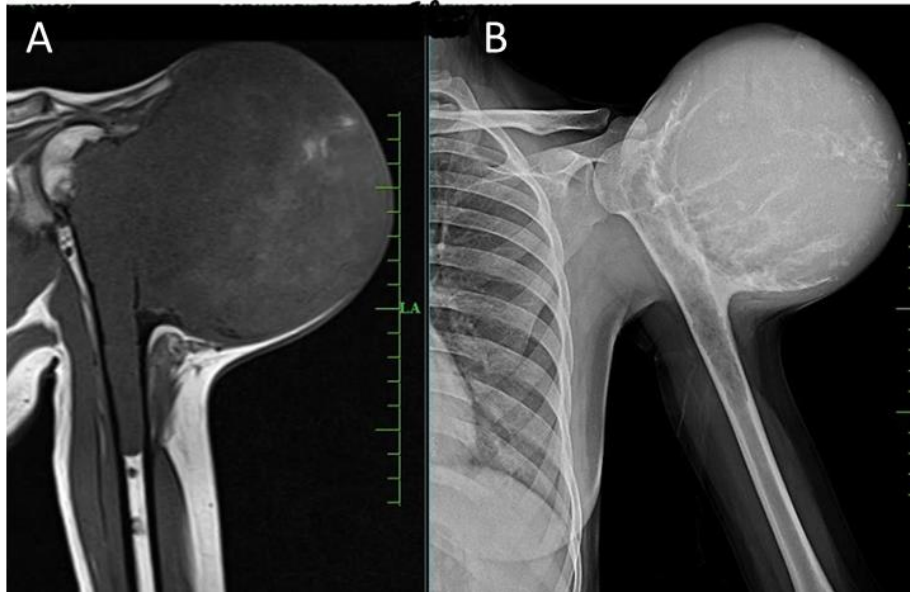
Osteosarcoma of humerus: MRI T1W (Fig A) and x ray shoulder (Fig B) images reveals lytic destruction in the upper 1/3rd shaft of the humerus, associated with large exophytic heterogeneously enhancing soft tissue component, sunburst periosteal reaction extending in the subcutaneous compartment. Diffuse heterogeneous marrow signals/extension of the disease involving upper and mid humeral shaft
